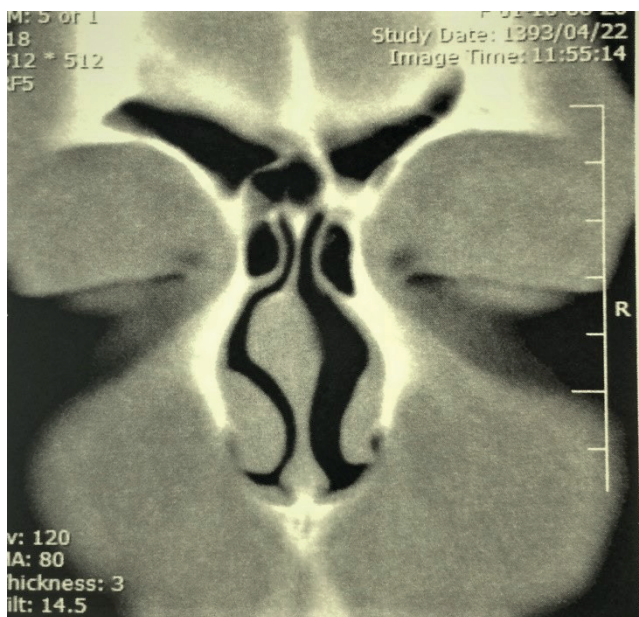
A coronal CT image of an agger nasi cell.
